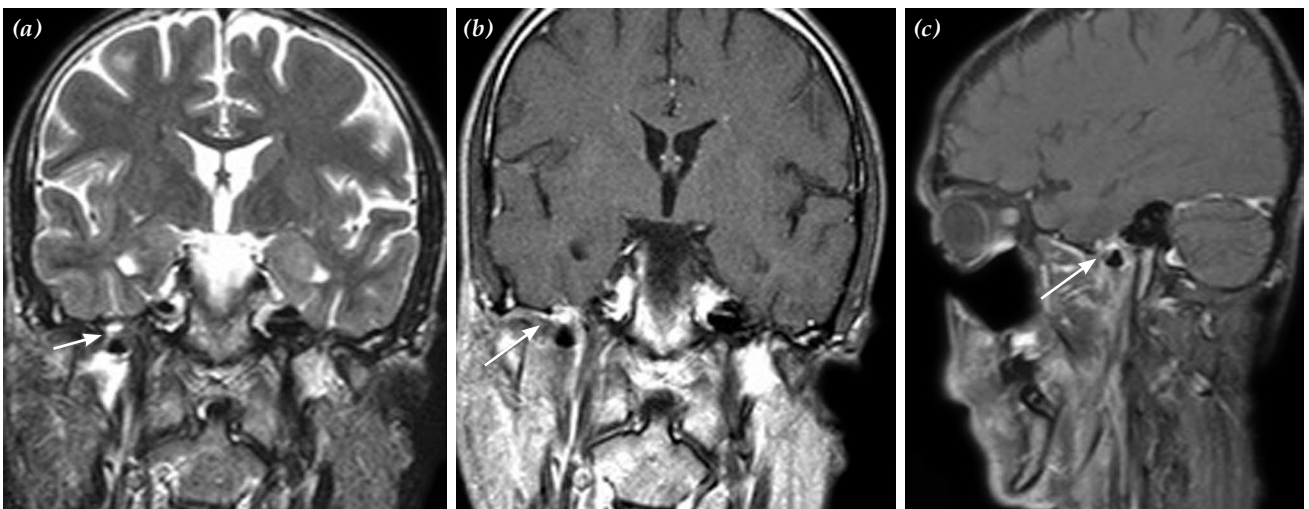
Postoperative magnetic resonance imaging. (a) Coronal T_{2a} image. (b) Coronal T_{1a} post-contrast injection, and (c) Sagittal section post-contrast injection. All of the images show total excision of the mass, but focal thickening and contrast enhancement of the dura mater (arrows).
